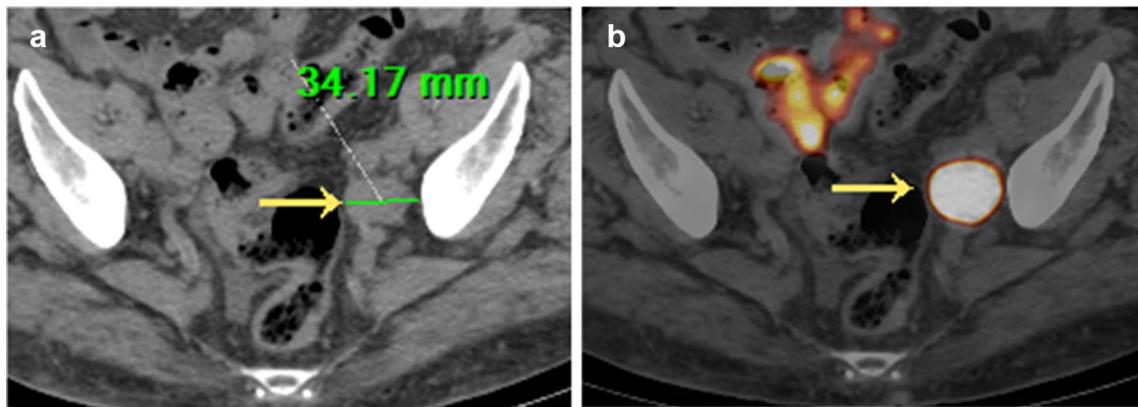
A 72-year-old man with newly diagnosed PC referred for initial staging (PSA level: 5.4 ng/mL; GS: 5+4). a Axial CT and b Axial ^{68}Ga -PSMA PET/CT images showing a large single regional
